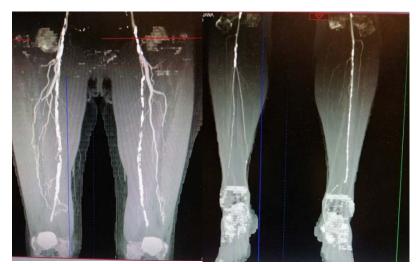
Multidetector computed tomographic angiography finding in a patient with an indication for femoropopliteal below-knee bypass.
